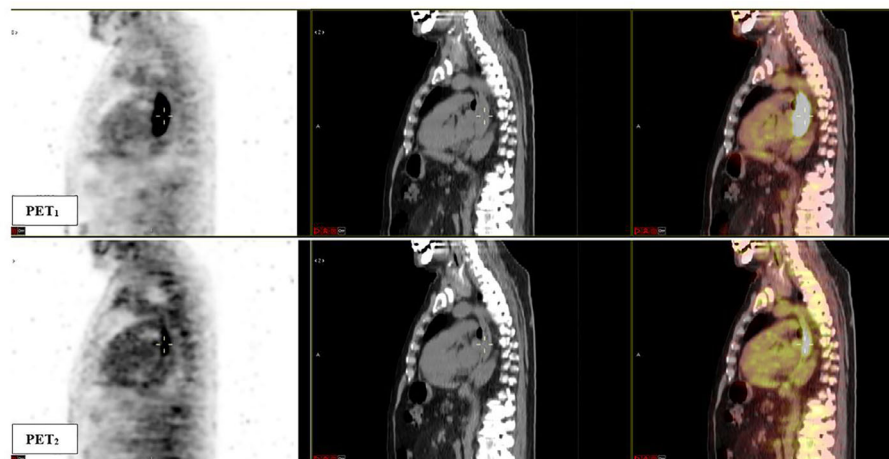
Sagittal fused ^{18}F -FDG PET/CT images obtained at baseline (PET₁) and after induction chemotherapy (PET₂). A significant response to induction chemotherapy (reduction in metabolic parameters) of the esophageal lesion can be observed. The patient was classified as TRG1 at final pathological examination. PET₁ parameters: SUV_{max} 26.9, SUV_{mean} 12.7, MTV 43.7 ml, TLG 553.9; PET₂ parameters: SUV_{max} 6.7, SUV_{mean} 3.2, MTV 15.9 ml, TLG 50.5.
